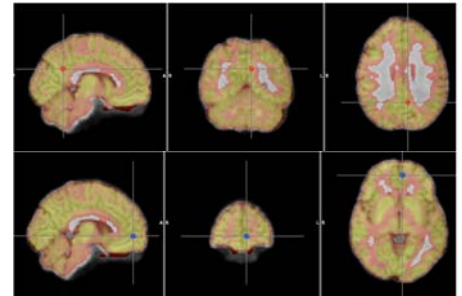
Co-registered T1-MNI, SUV-MNI, and PCC mask (red, top) and aMPFC mask (blue, bottom).
